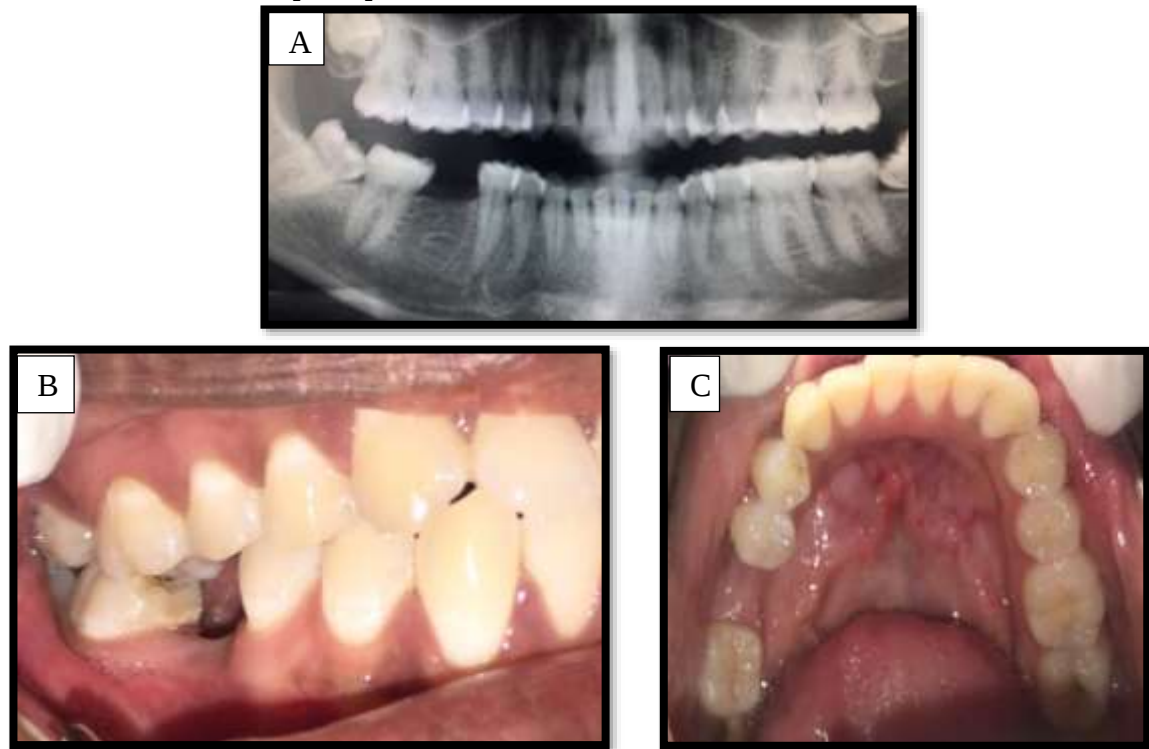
Pre-operative Images (A) Orthopantomogram (OPG) Assessment. (B,C) Intraoral Examination
